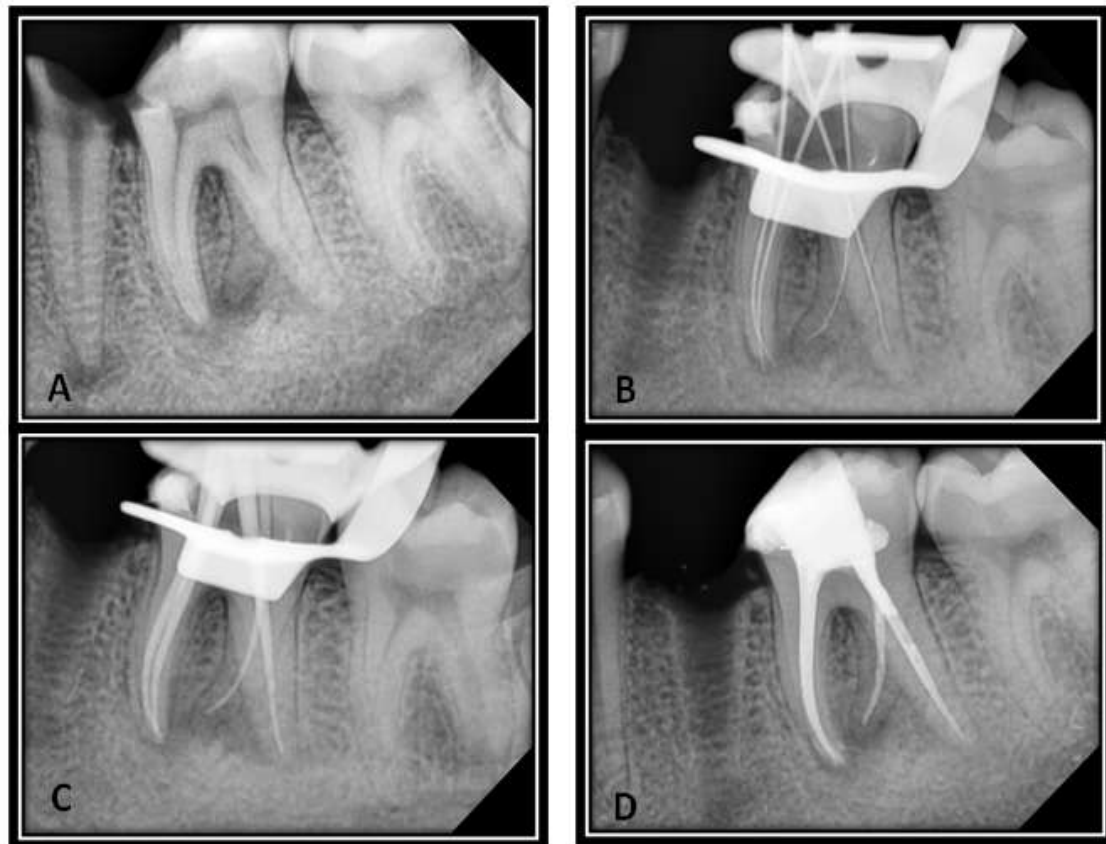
(a) Pre-operative radiograph, (b) determination of working length, (c) gutta percha master cone fit, (d) post-operative radiograph.
